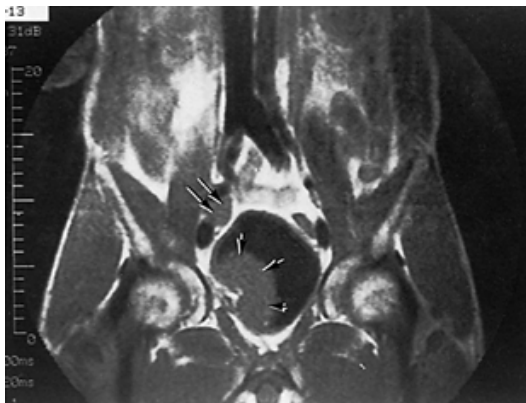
23. Coronal T₁-weighted magnetic resonance imaging scan of large muscle invasive bladder cancer (*short arrows*) and tumorous pelvic lymph node (*long arrows*).
